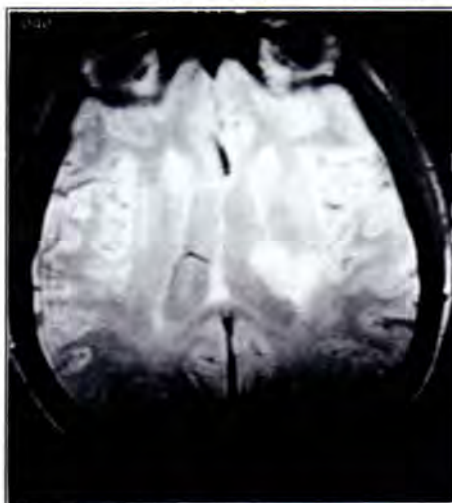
Primary CNS lymphoma. This proton density MR image is that of a 42 year old AIDS patient.
